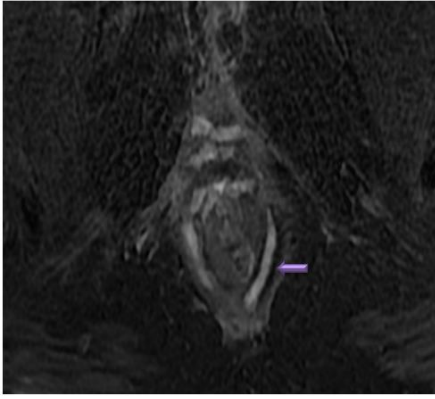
Axial T2 weighted FS MR image showing inter-sphincteric fistula with high signal intensity fluid collection in the inter-sphincteric space – GRADE 2
